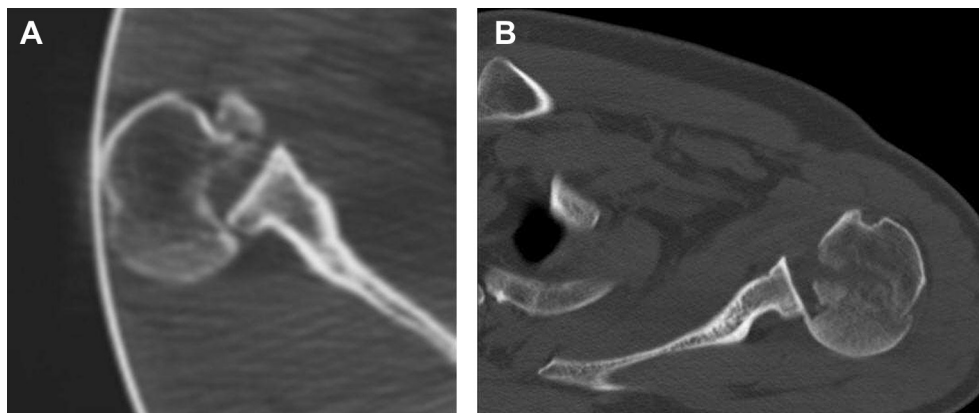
Computed tomography (CT) confirms posterior dislocations of the shoulder joint and their association with a reverse Hill–Sachs lesion. (A) CT of the right shoulder of Case 1. (B) CT of the left shoulder of Case 2.
